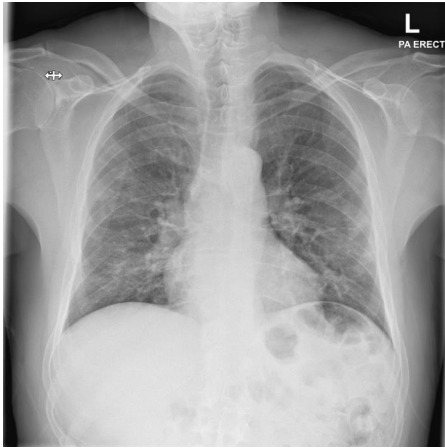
Chest X-ray revealed bilateral opacifications that were suspicious for COVID-19.
